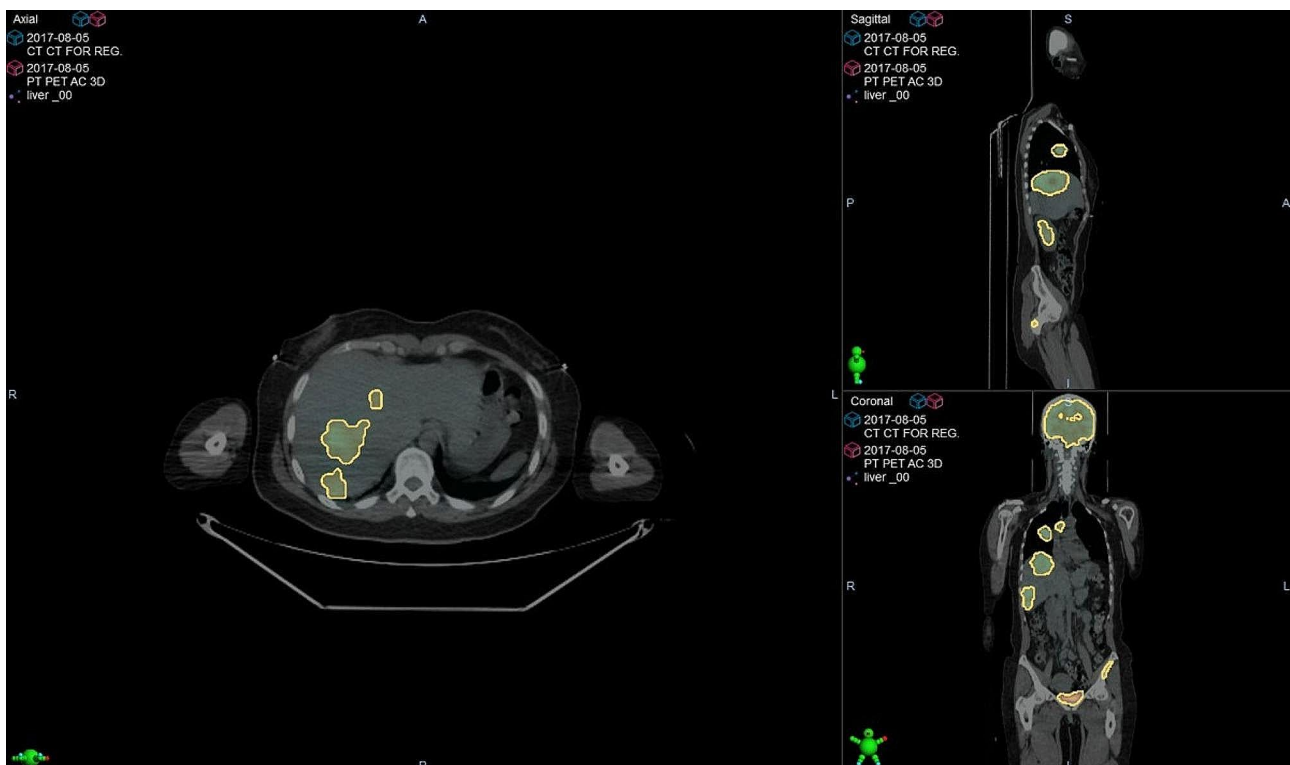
Positron emission tomography/computerized tomography (PET/CT) images of a patient with liver metastases with auto contouring of all FDG avid lesions with an SUV \geq 4
